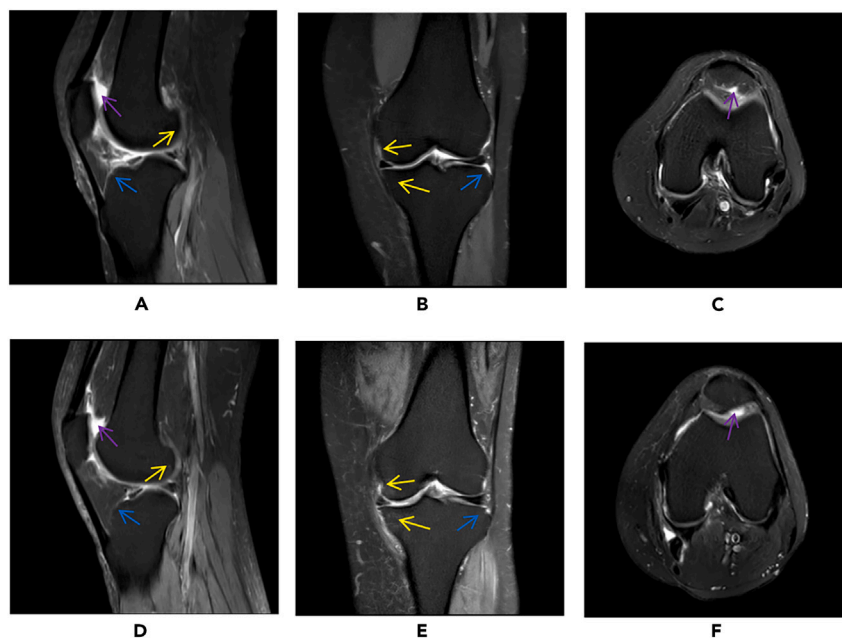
Baseline Knee MRI
